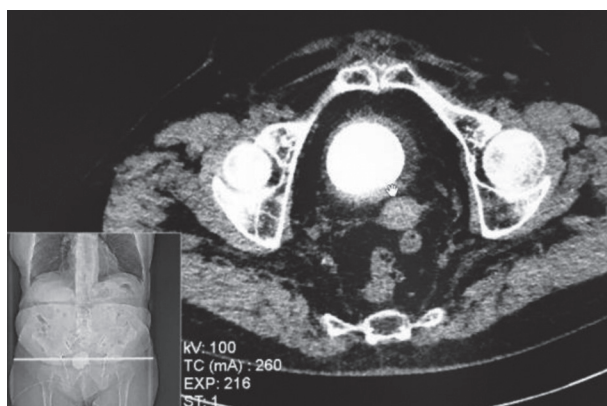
Abdominal CT showing bladder stone
